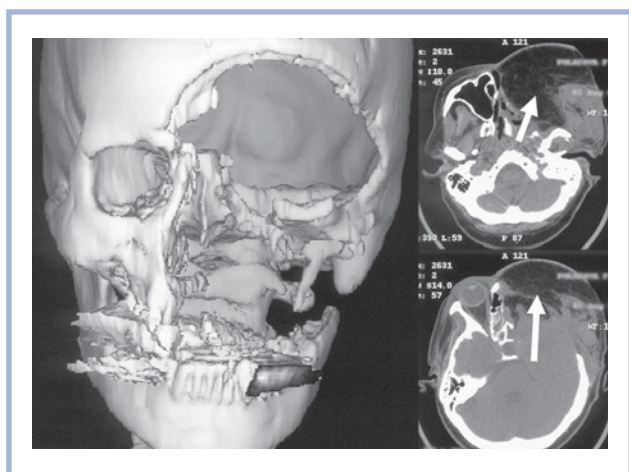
CT one month after the operation.
